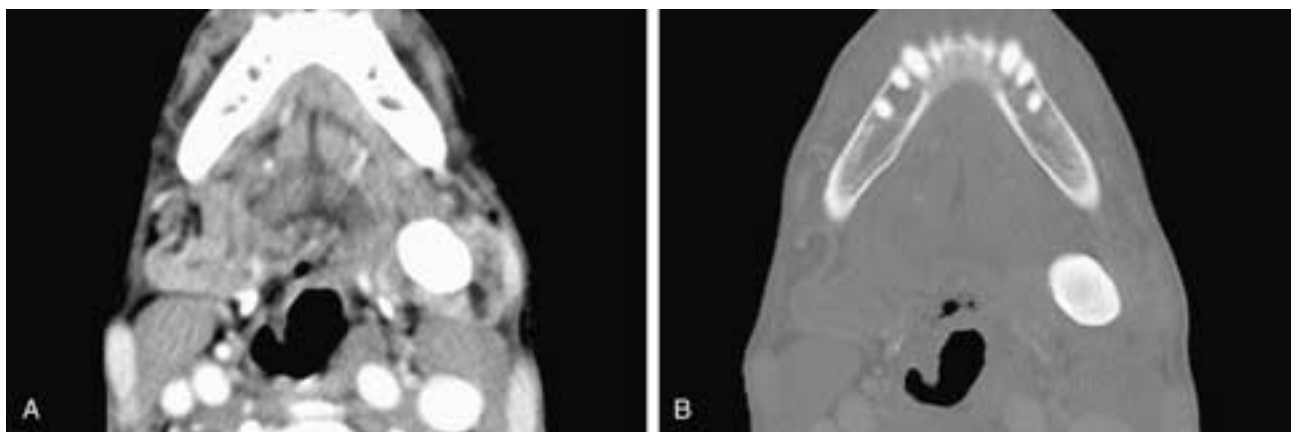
Axial CT scans viewed at narrow (A) and wide (B) windows show a large laminated calculus in the hilum of the left submandibular gland. There is some intraglandular ductal dilatation. This patient had submandibular sialolithiasis and early sialadenitis.
